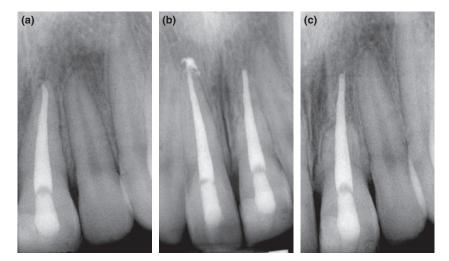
(a) The left central maxillary incisor developed pulp necrosis with subsequent root-canal treatment 3 months following lateral luxation in a 15-year-old girl. (b) The 2-year radiograph shows beginning replacement root resorption in the apical portion of the root. (c) The 4-year radiograph shows advanced replacement root resorption in the apical half of the root.
